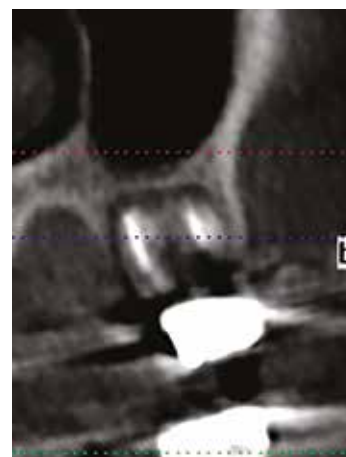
CBCT cross section of the maxillary molar area pretreatment demonstrating periapical pathology associated with failed endodontics that will necessitate extraction of the molar.
